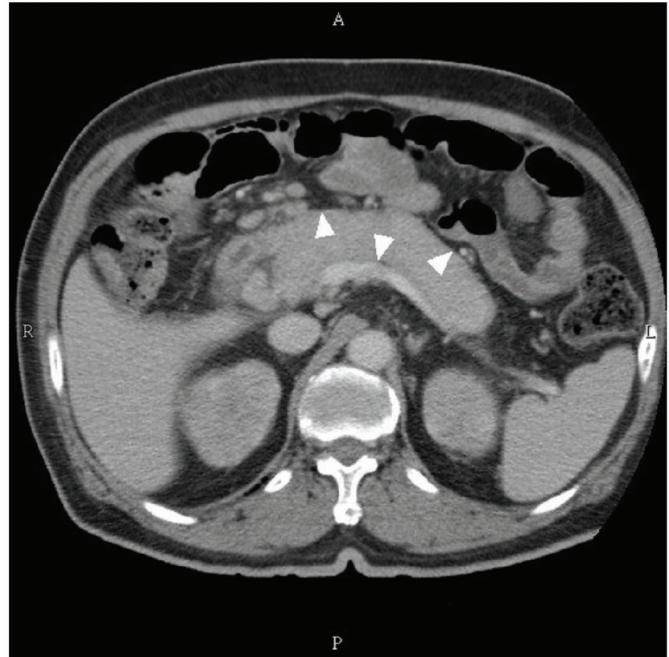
Contrast-enhanced abdominal computed tomography revealing a diffuse enlargement of the pancreas (white arrowheads).
